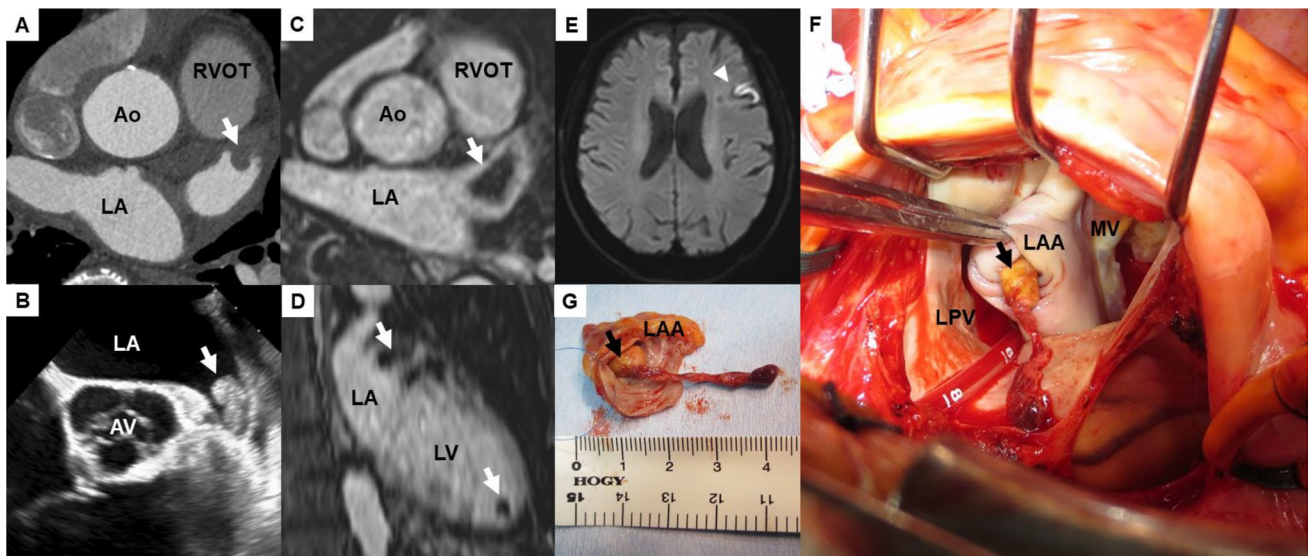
A Computed tomography angiography. B Transesophageal echocardiography. C–E Magnetic resonance imaging. F and G Intraoperative findings. White and black arrows, cardiac thrombus; white arrowhead, acute cerebral infarction
